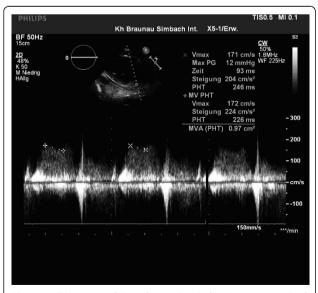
Continuous wave (CW) - spectral Doppler tracing indicating mitral stenosis with a mitral valve area less than 1.0 cm<sup>2</sup>
